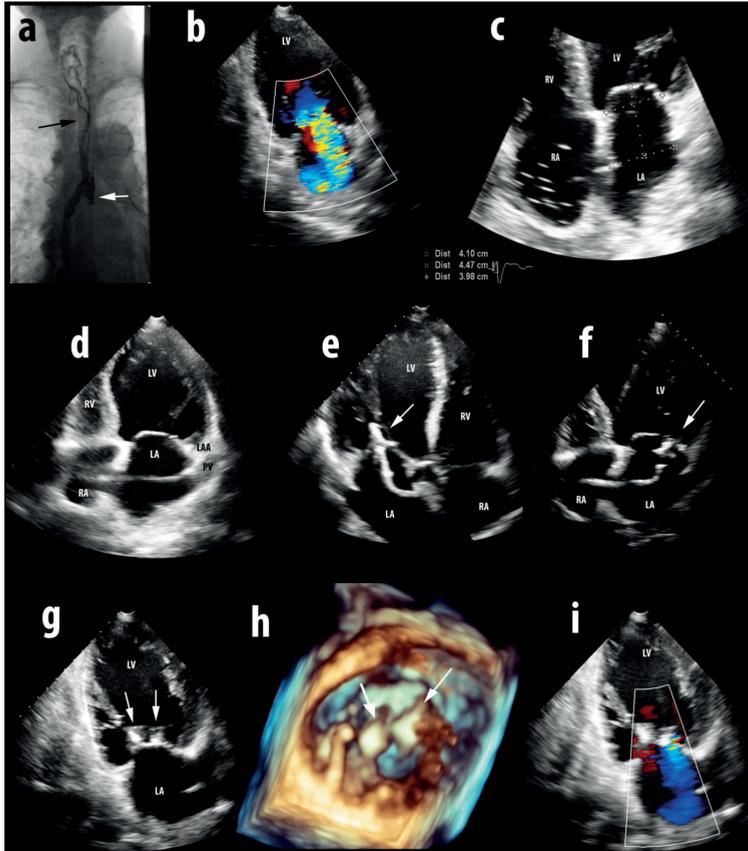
MitraClip Placement Guided by Transthoracic Echocardiography
